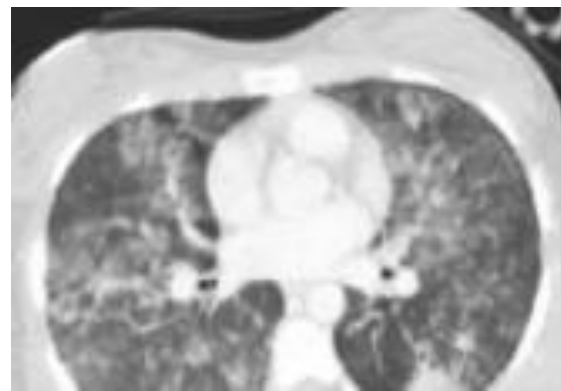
CT scan in ARDS patient
